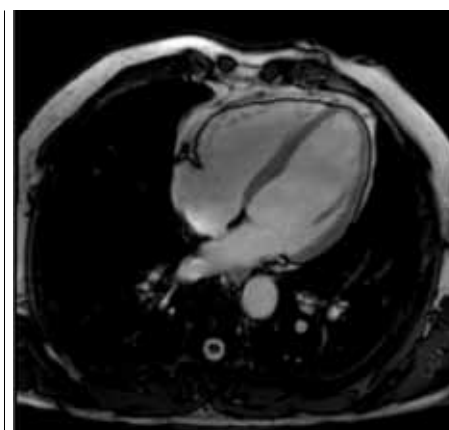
Cardiac MRI (Four chamber view)
